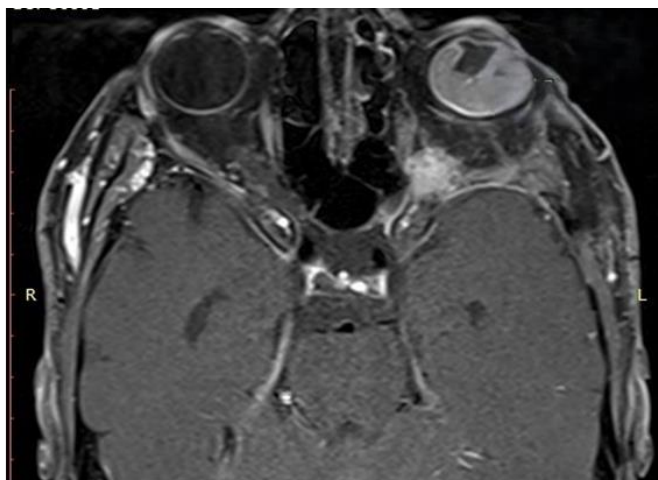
A fragment of a magnetic resonance imaging scan of patient O., 56 years old.
